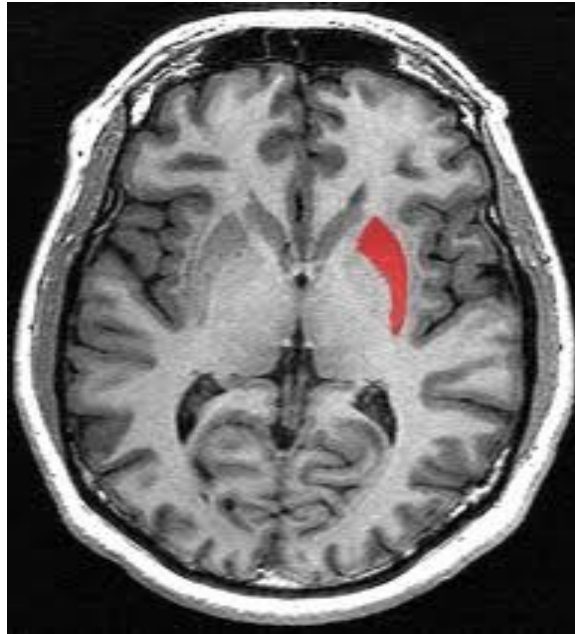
Axial MRI T1W image of brain shows the putamen (<https://en.wikipedia.org/wiki/Putamen> 2/2/2013).
